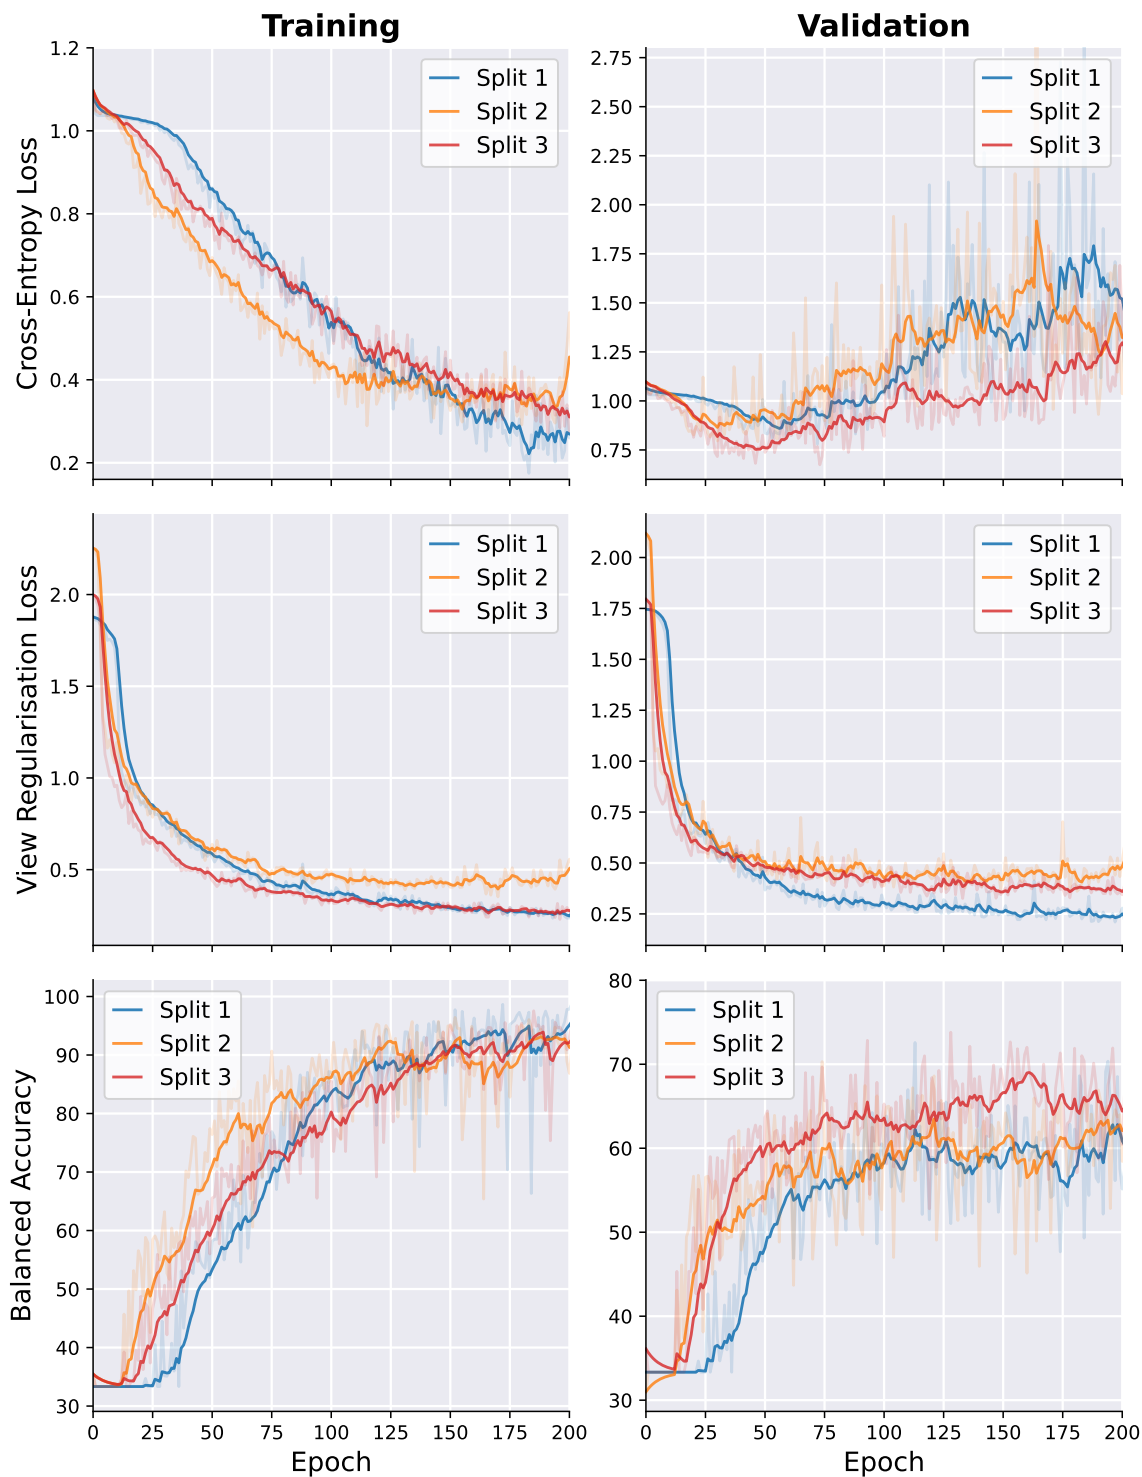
Training and validation performance of the supervised attention multiple instance learning model across the pre-defined cross-validation splits of the Tufts Medical Echocardiogram Dataset. Hyperparameters were set for each split according to the reported values in (Huang et al., 2024). Cross-entropy loss, view regularisation loss, and balanced accuracy are shown from top to bottom. The left column presents the results for the training set, while the right column shows the results for the validation set. Smoothing was applied to the raw output values (seen in matching transparent colors) to help visualisation.
